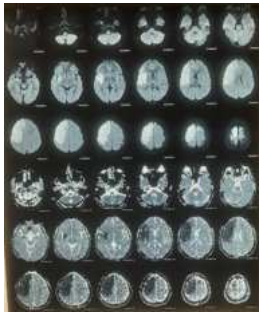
MRI showing Right MCA territory infarct.
